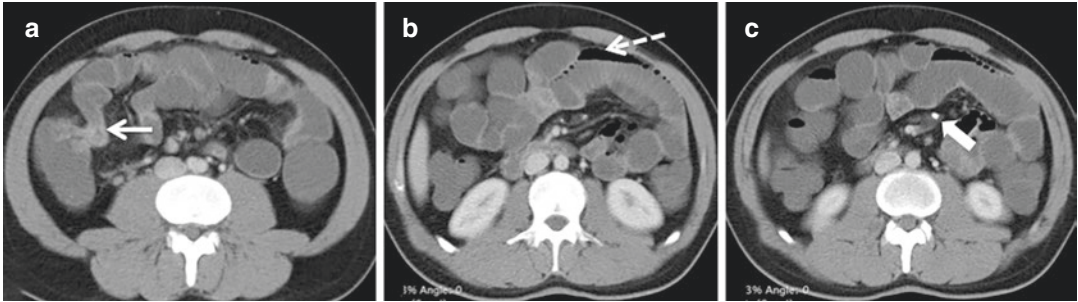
32-year-old man who presented with recurrent abdominal distension. CT enterography was done after ingestion of 2 L of PEG solution (an osmotic laxative) by the patient. (a–c) Axial CT enterography images show circumferential mural thickening of the terminal ileum
